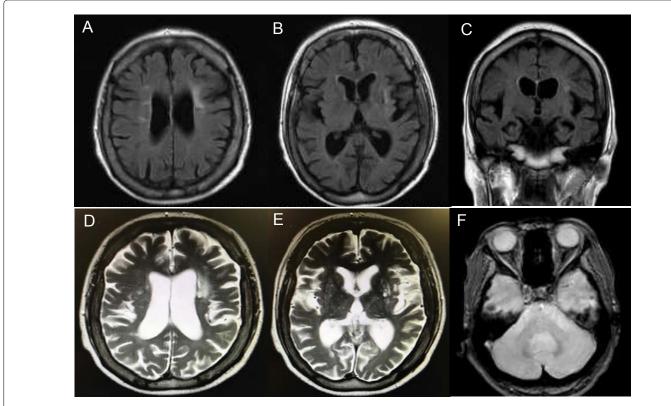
Axial and coronal T2-weighted and Fluid-Attenuated Version Recovery (FLAIR) Magnetic Resonance Imaging (MRI) images scans showing multiple cerebral infarcts located around the corona radiata and at the left basal ganglia (A-C). Axial T2 star- weighted images showing a right putaminal haemorrhage (D-F).
